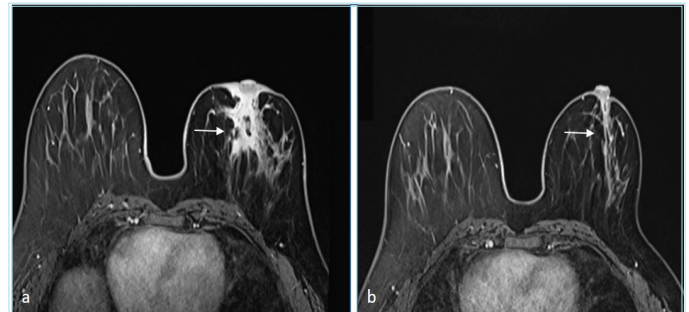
Post-contrast T1-weighted (T1W) breast magnetic resonance images of a 38-year-old female patient show a heterogeneous irregularly shaped area of enhancement in the right retroareolar region (a), one year after treatment follow-up images of the same patient (b), show near-complete regression of the findings (thin arrows). The pathology result confirmed “granulomatous mastitis”
